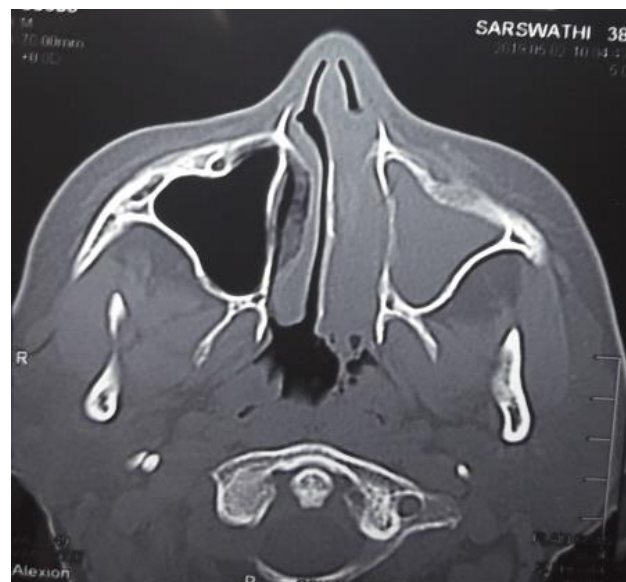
The above axial CT image of maxillary sinus shows focal bony hyperostosis in left anterolateral wall which signify disease attachment
